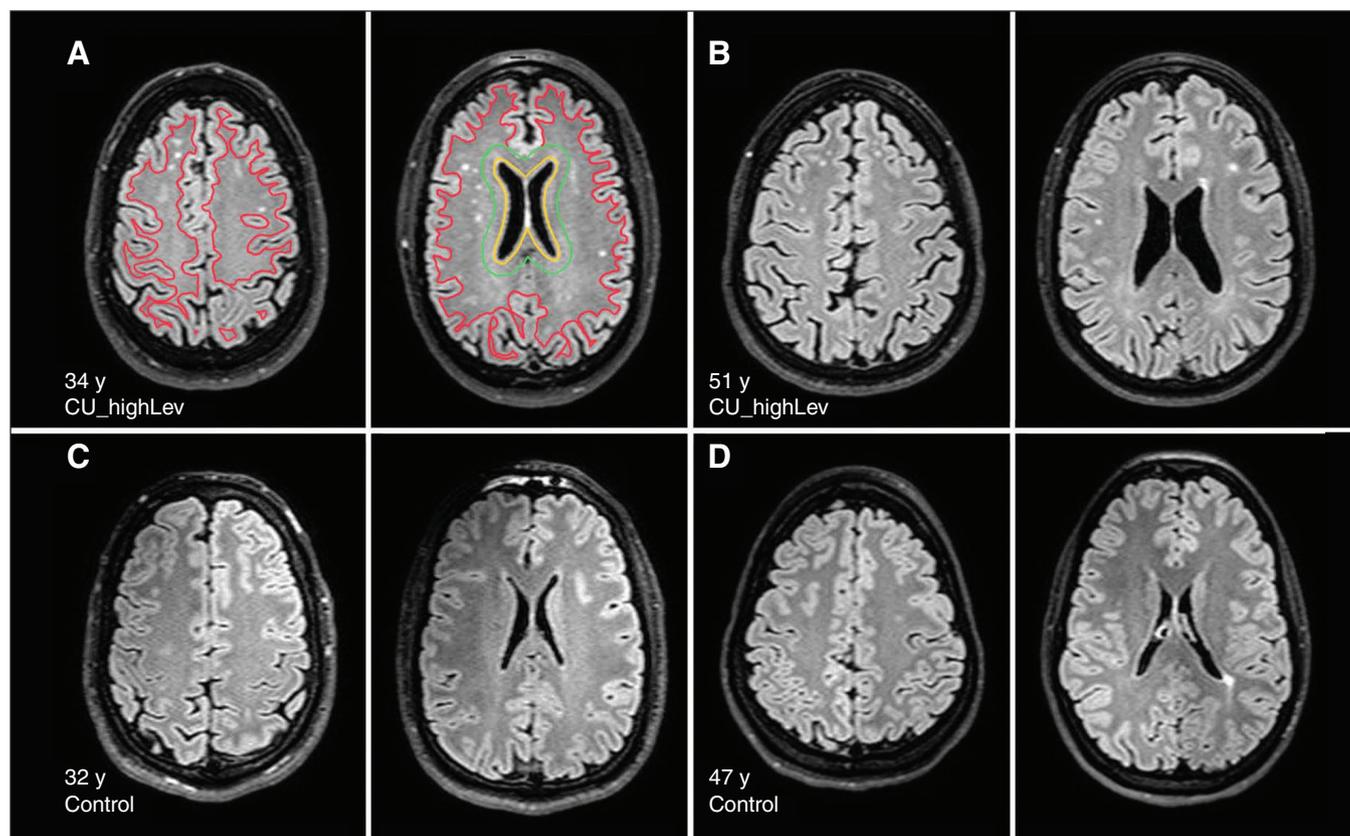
White matter hyperintensities at different ages in controls and cocaine users with high levamisole exposure (CU_highLev). Representative FLAIR images (2 slices each) of (A) a younger cocaine user and (B) an older cocaine user, both with high levamisole hair concentrations; FLAIR images of (C) a younger control participant and (D) an older control participant. In A, different white matter hyperintensity locations are visualized according to Kim and colleagues⁴¹: superficial cortex to red line, juxtacortical; between red and green lines, deep; between green and yellow lines, periventricular; between yellow line and ventricles, juxtaventricular. FLAIR = fluid attenuated inversion recovery.
